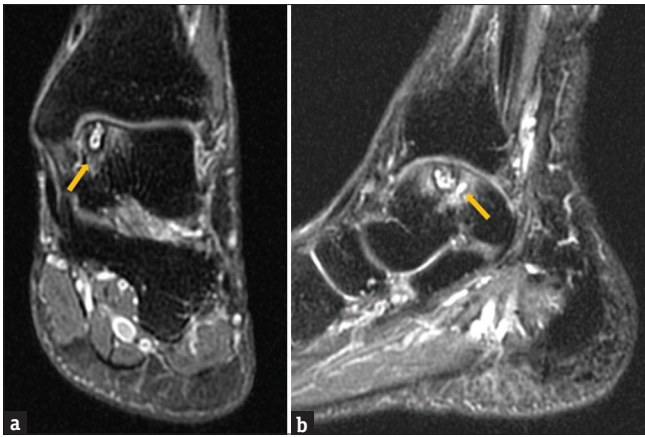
MRI examination revealed an Anderson IIB lesion over left medial talar dome (arrow). (a) AP view of the lesion. (b) lateral view of the lesion
